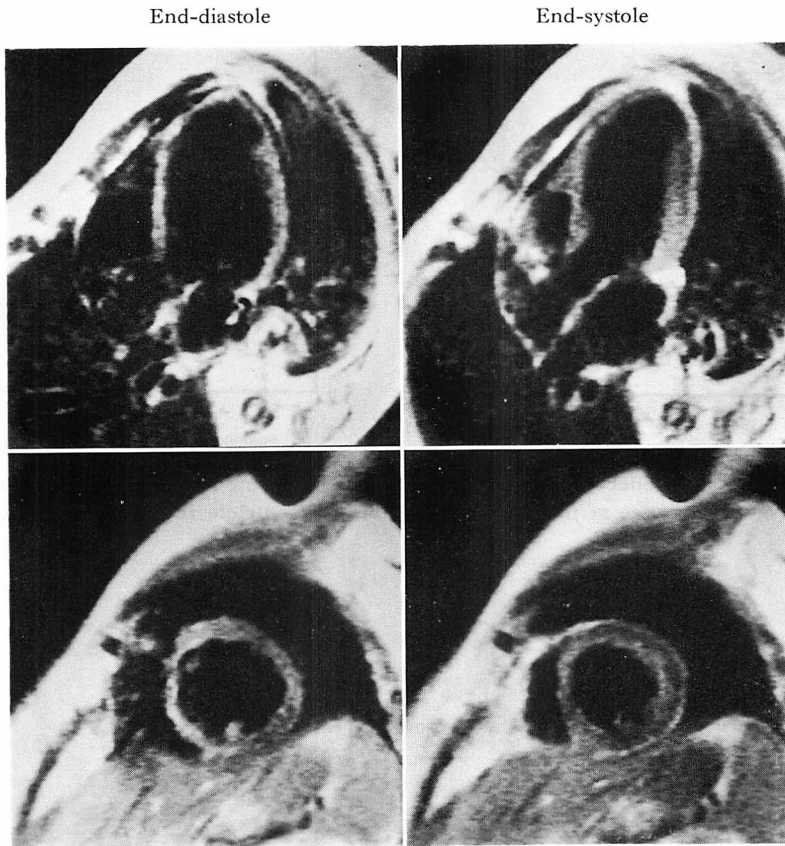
Magnetic resonance imaging in the case of anterior myocardial infarction.
